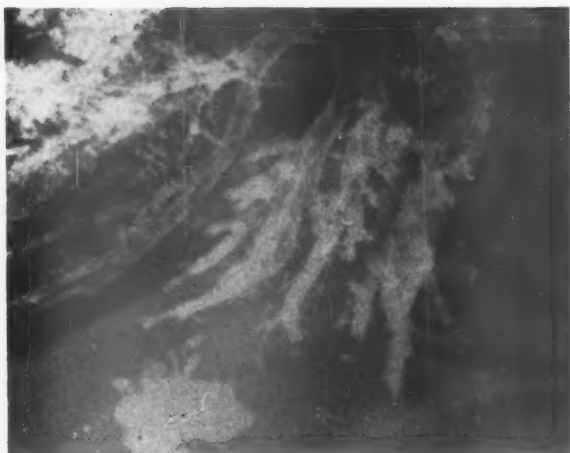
(a).—Left oblique bronchogram of a girl aged 7 years, showing the dilated lower lobe bronchi and the lingula lobe bronchi displaced downward and slightly dilated. The patient gave no history of cough only loss of weight and she easily became tired. Pulmonary collapse of the left lower lobe was revealed on a radiograph two months previously.
